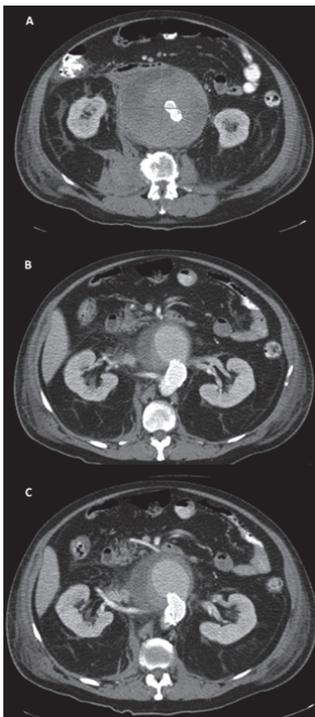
Computed tomography angiography of the abdomen of (A) transverse image of 12 x 11 cm abdominal aortic aneurysm after endovascular repair for ruptured abdominal aortic aneurysm; (B) Type Ia endoleak, stent graft and patent left and (C) right renal artery.
